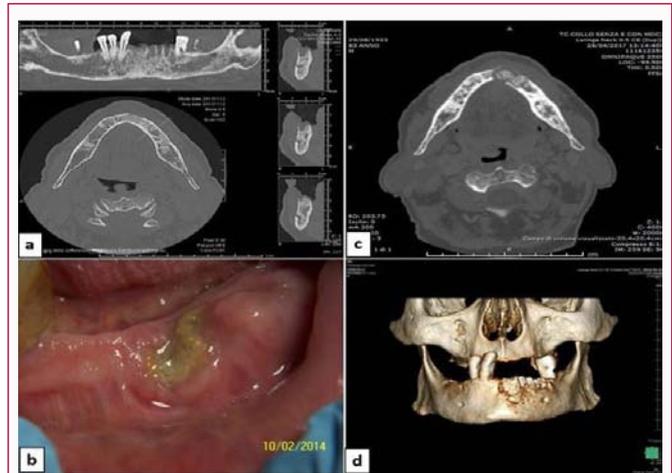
a) The initial computerized tomography (CT) of the facial bones reveals mandibular bone trabeculation broadly and markedly not homogeneous with areas of extensive osteo-rarefaction on both sides. In the median and left paramedial site the edentulous alveolar crest appears not homogeneous, with jagged edges, irregular areas of bone sclerosis, interruption of the cortical profiles and periosteal reactive thickening on the vestibular side; b) Clinical appearance of bone exposure in the left paramedial area of the mandible persisted for 3 months of therapy; c) CT of the facial bones without and with contrast medium performed 4 and a half years later reveals marked osteonecrosis alterations of the mandible bone corresponding to the area of missed teeth, with marked morphological and structural change? The necrotic bone affects the dental alveolus that appears no longer in continuity with the rest of the mandible. An edema of the soft tissues is associated; d) Three-dimensional reconstruction of the CT Dental scan of the figure 1c.
